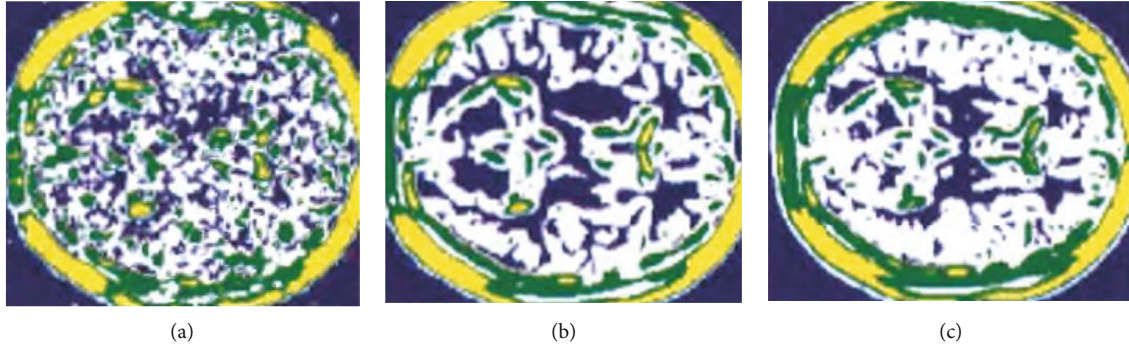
Denoising image processing process. Note: (a) the obtained original noise image, (b) the clustering result after 10 cycles, and (c) the clustering result of denoised MRI.
